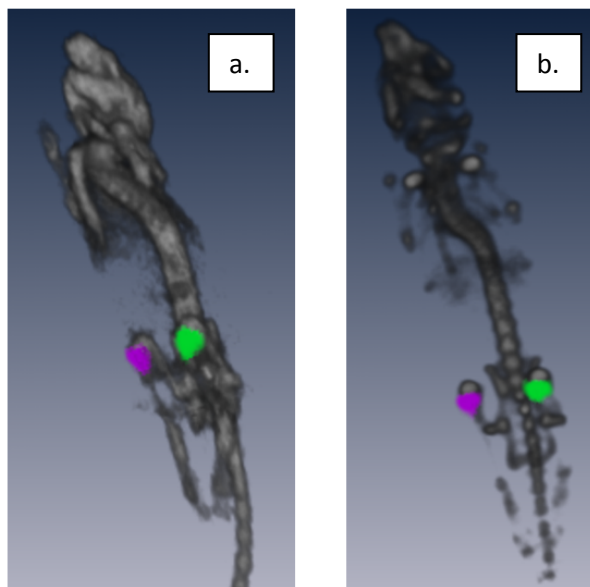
Shows representative ROIs for limb 1 and limb 2, purple and green, respectively for both (a) PET and (b) SPECT.
